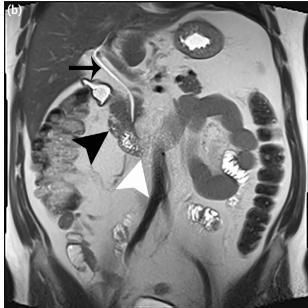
(a) Ectopic pancreas showing protrusion to the stomach lumen at the level of the great curvature of the stomach antrum in the T2-weighted axial section, (b) Note that there is no significant dilatation in the ductus choledochus (thin arrow ductus choledochus, black arrowhead pancreatic uncinate process, and white arrowhead duodenum).
